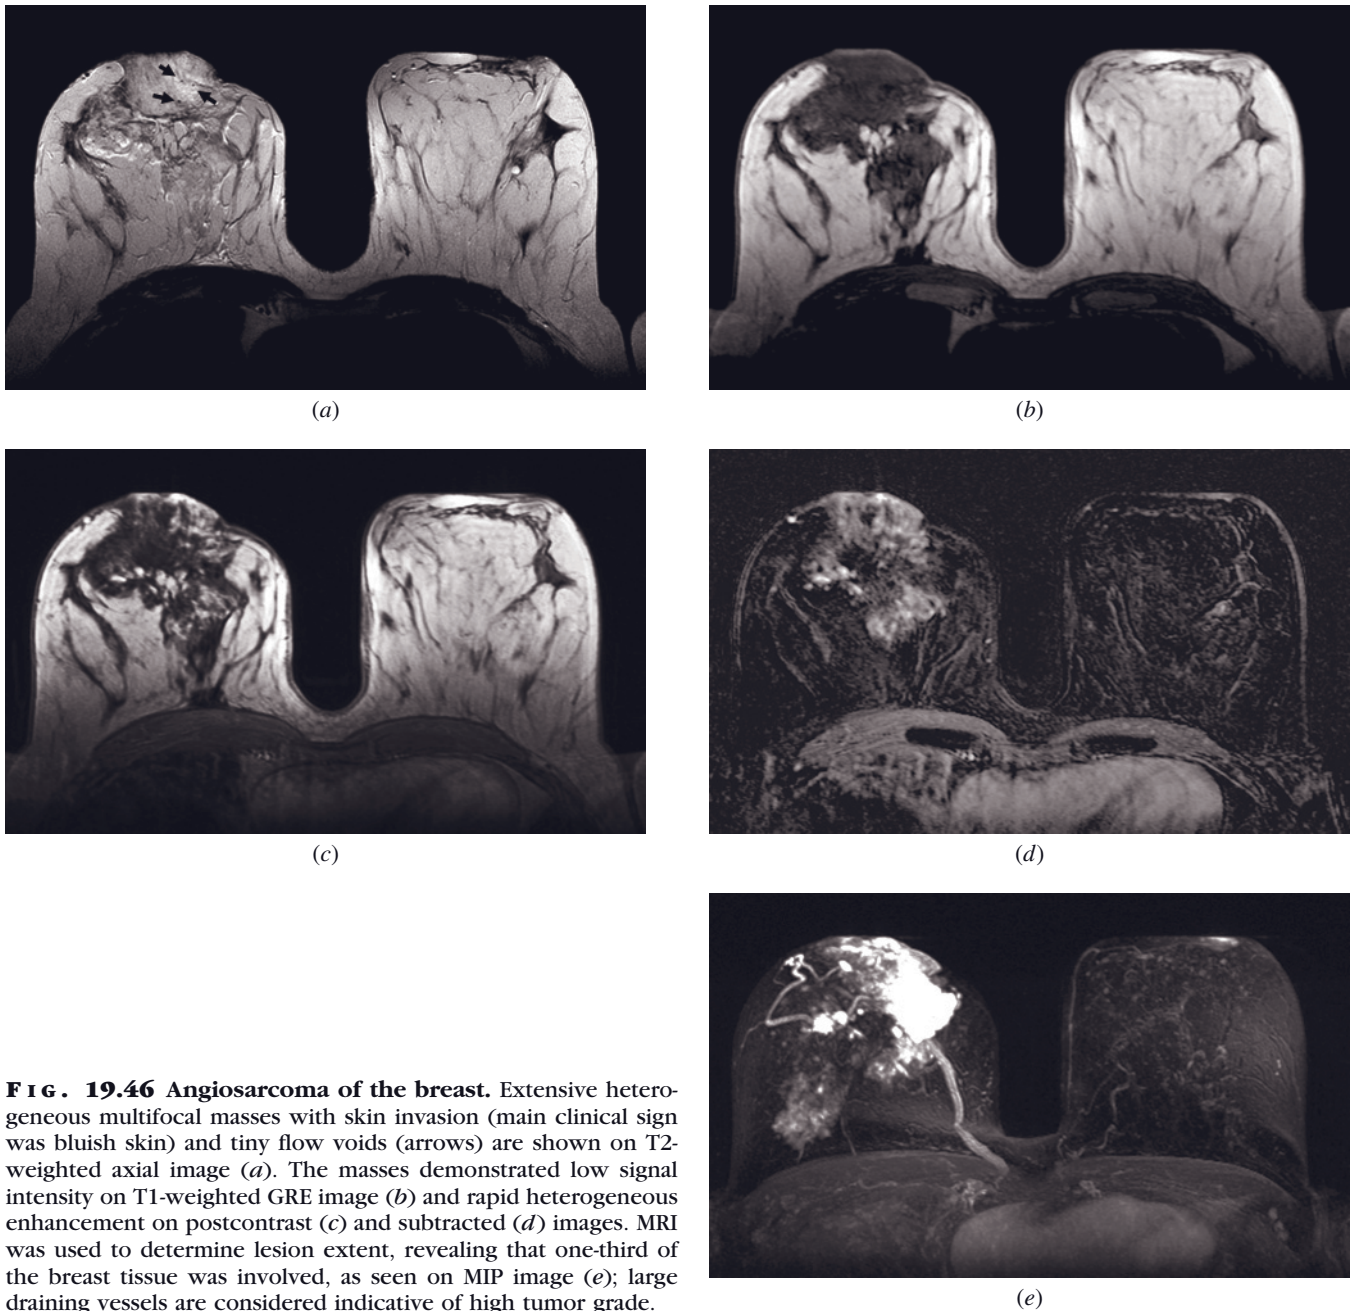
Angiosarcoma of the breast. Extensive heterogeneous multifocal masses with skin invasion (main clinical sign was bluish skin) and tiny flow voids (arrows) are shown on T2-weighted axial image (a). The masses demonstrated low signal intensity on T1-weighted GRE image (b) and rapid heterogeneous enhancement on postcontrast (c) and subtracted (d) images. MRI was used to determine lesion extent, revealing that one-third of the breast tissue was involved, as seen on MIP image (e); large draining vessels are considered indicative of high tumor grade.
